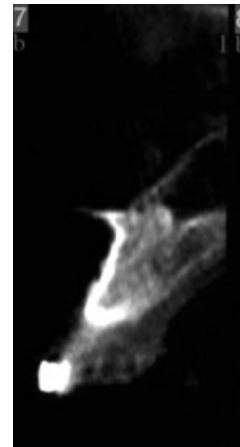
CT radiograph of the alveolar ridge of the decoronated tooth site prior to implant placement.
